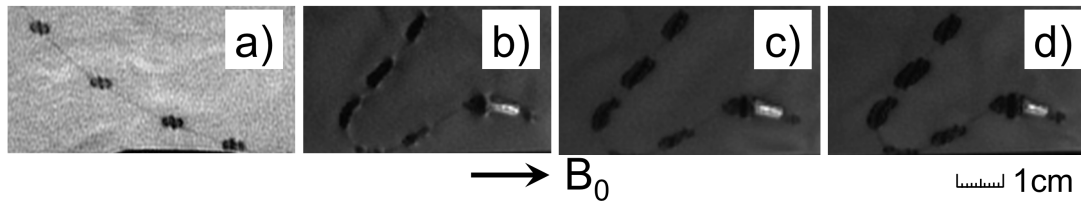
MR images (according to Table 3.3) of a sidewinder II catheter (SW2 - Table 3.1) with a wRC on the tip and FePt nPs markers along the shaft - Figure (a) was obtained (GRE) according to the ASTM protocol [30] with a guidewire (without markers) in place. Figures (b - d) were obtained with a rtMRI sequence (FGRE) and demonstrate how the artefact can be manipulated by varying TE ((b) TE = 2.5 ms, (c) TE = 5 ms, (d) TE = 10 ms).
